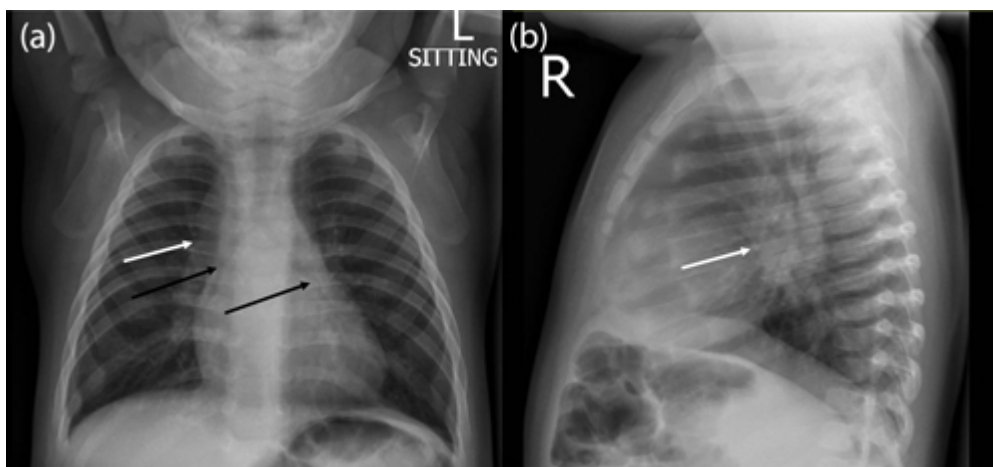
(a) Anteroposterior and (b) lateral chest radiographs on treatment initiation showing enlarged right hilar and subcarinal nodes (white arrows) with bilateral compression of main bronchi (black arrows) and resultant hyperinflation of both lungs. ↩
